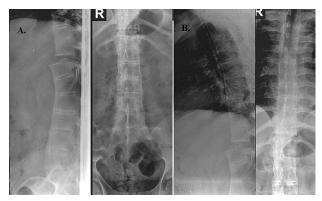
Thoracic and lumbosacral X-Rays in case 2 show diffuse bambooing of spine with a fracture-dislocation at T11-T12 level.
